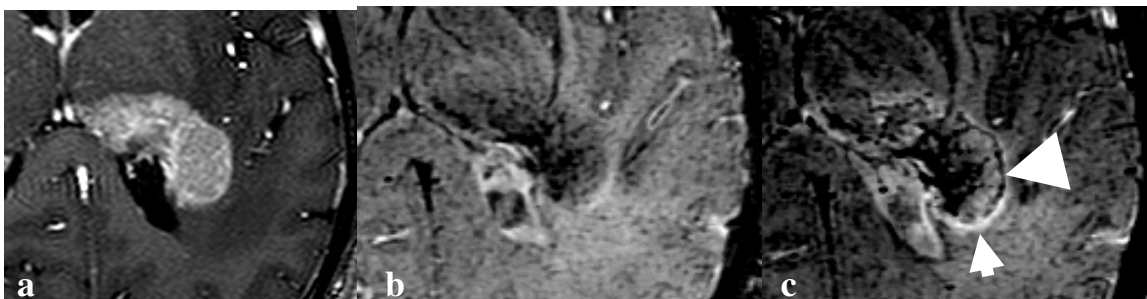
CNS malignant lymphoma. Post-contrast 3D T1-weighted image (a) shows enhanced mass lesion around the left lateral ventricle. Pre-contrast SWI (b) shows internal structures and blood products in the tumor. Post-contrast SWI (c) shows low intensity rim (arrowhead) and surrounding enhancement (arrow), which suggests breakdown of the blood brain barrier.
